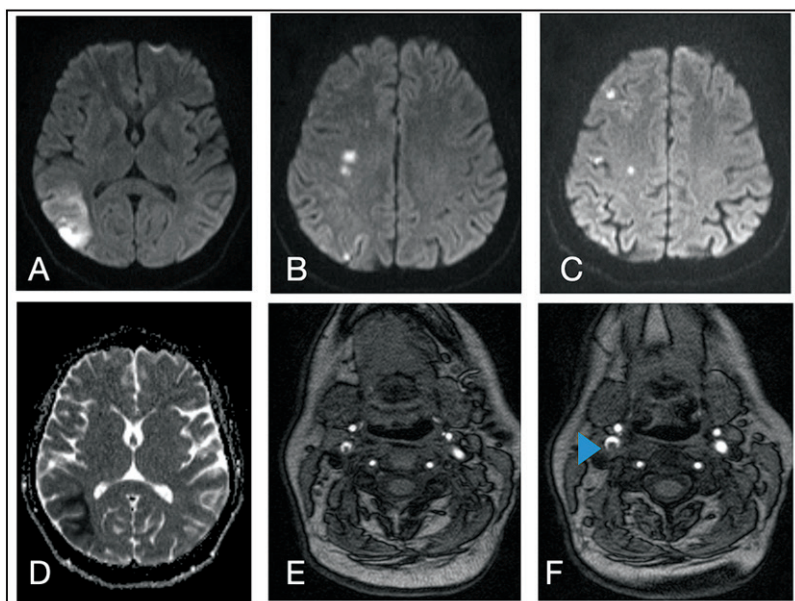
MRI Brain Axial DWI showing acute infarcts (A-D) MR Angiography showing carotid dissection (E-F)
